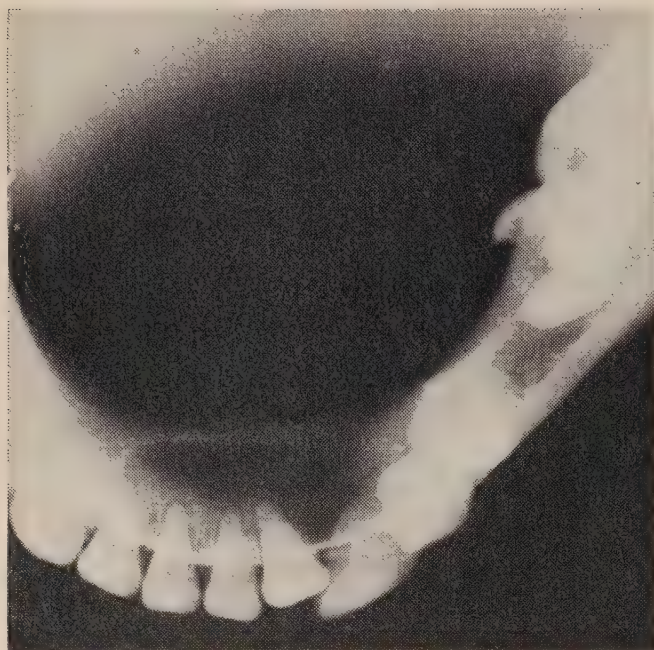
Occlusal radiograph showing lingual expansion of mandible.
